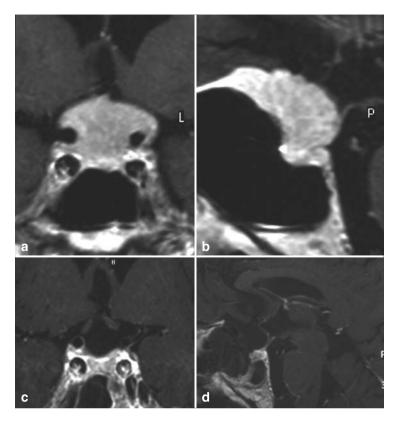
a, b) Coronal and sagittal pre-operative MRI images showing a case of tuberculum sellae meningioma. c, d) Coronal and sagittal post-operative MRI images of the same patient confirming the total removal of the lesion
